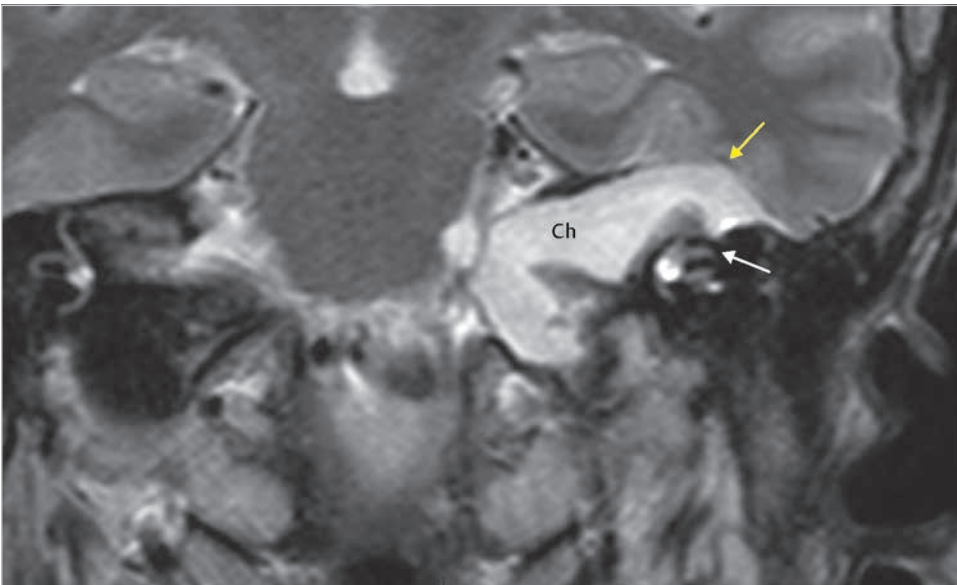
MRI (coronal cut) shows the petrous bone cholesteatoma that from the supralabyrinthine compartment (*white arrow*) extends superiorly towards the temporal lobe (*yellow arrow*). Ch, cholesteatoma.
